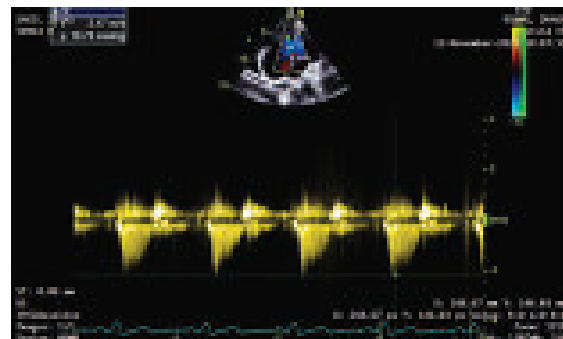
TTE 2D & color guided Spectral Doppler showing TR gradient 19 mmHg (PASP= 27 mm of Hg)
